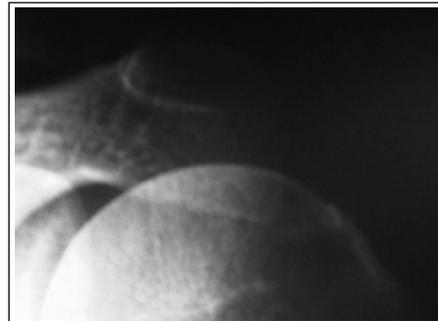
X-ray control after the application of shock waves. The calcifications have disappeared.
